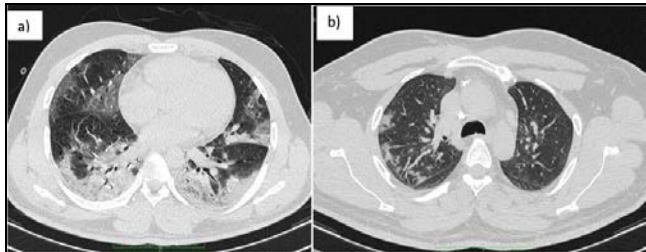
Axial chest CT image A. in lung window settings of a 51-year-old COVID-19 patient at the level of carina obtained at admission reveals consolidation with air bronchogram B. in lung window settings of a 64-year-old COVID-19 patient with pulmonary vessel dilatation
